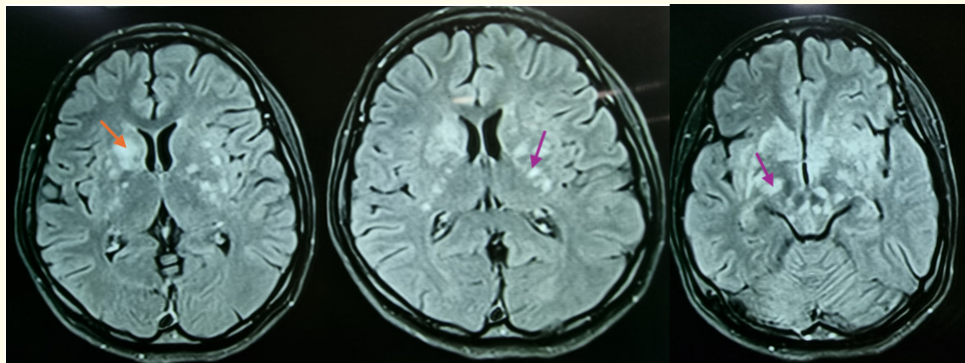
Well defined FLAIR hyperintensities in right caudate nucleus(orange arrow) and along virchow robin spaces(purple arrow).
